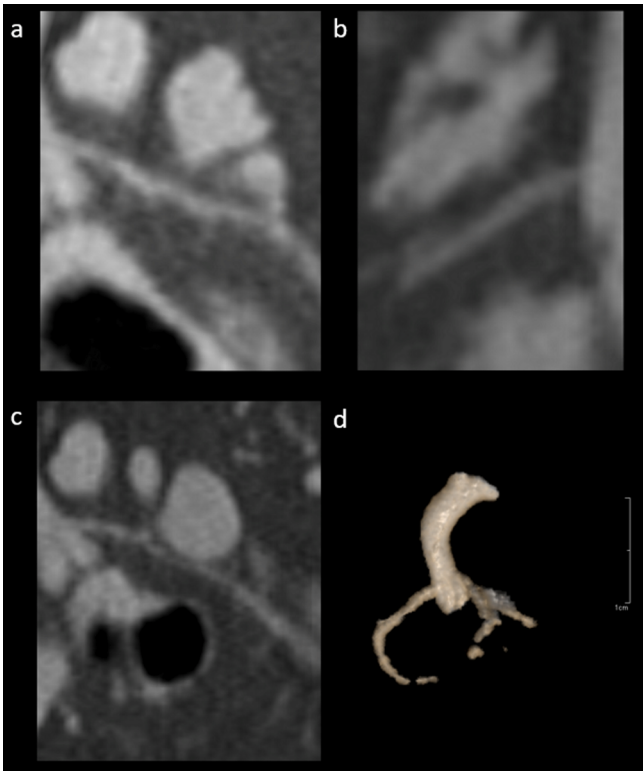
Fetus deceased at 175 days of gestational age. The post-mortem interval between the expulsion and the examination is 20 months. CT angiography image using MIP after arterial opacification shows very small caliber arteries such as left anterior descending artery (a), right coronary artery (b) and circumflex artery (c). The CT angiography image using the Cinematic Rendering Technique (CRT) makes it possible to visualize the sinuses of Val-salva as well as the coronary arteries (d).
